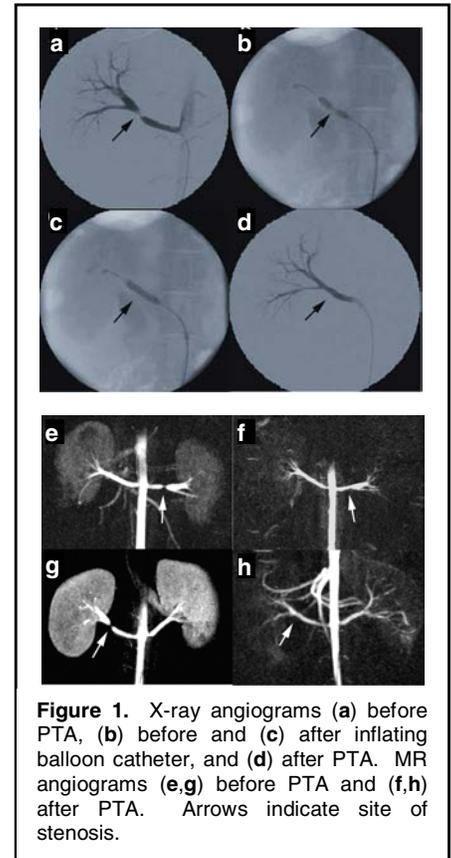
X-ray angiograms (a) before PTA, (b) before and (c) after inflating balloon catheter, and (d) after PTA. MR angiograms (e,g) before PTA and (f,h) after PTA. Arrows indicate site of stenosis.
